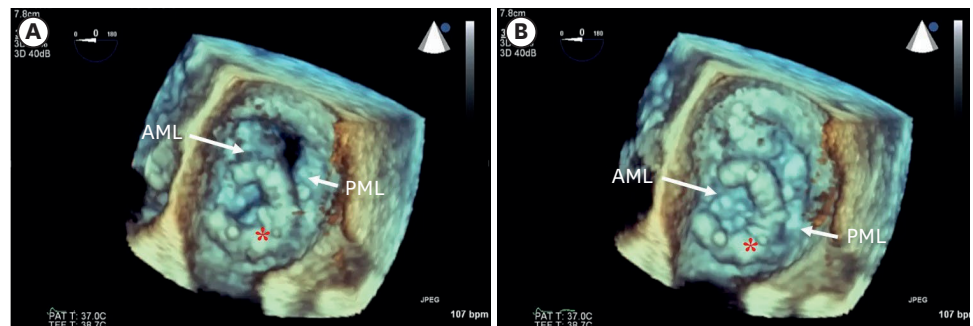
Real time 3D TEE. Real time 3D TEE confirmed the mitral annuloplasty ring dehiscence (red asterisk). (A) Real time 3D TEE image of diastolic phase. (B) Real time 3D TEE image of systolic phase. 3D TEE = three-dimensional transesophageal echocardiography, AML = anterior mitral leaflet, PML = posterior mitral leaflet.
